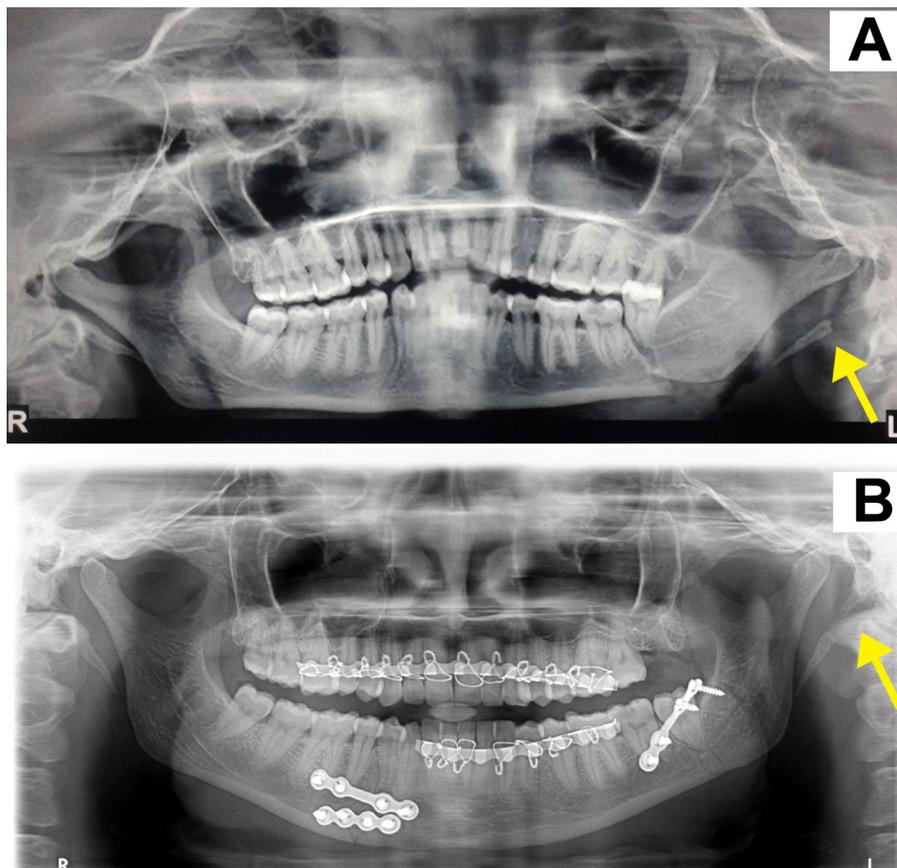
Orthopantomogram of patient. (A) Preoperative OPG demonstrating fracture of left angle, left styloid (arrow) and right body. (B) Immediate postoperative OPG showing ORIF mandible and spontaneous reduction of styloid (arrow).
